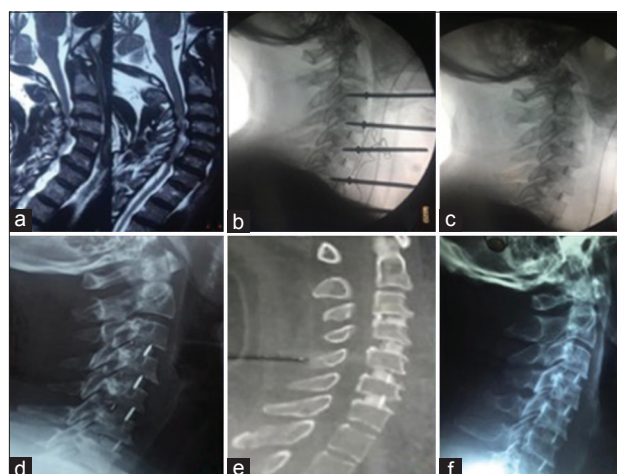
Type 2A fusion case “2A as bridging bone not anterior but through the disc space,” (a) MRI of C3–C7 case, (b) intraoperative, (c) immediate postoperative, (d) 3-month follow-up, (e) 3-month follow-up CT scan, (f) 24-month follow-up
